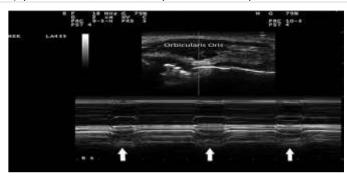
M-mode ultrasound of orbicularis oris muscle in a patient with synkinesis. The image was captured while the patient blinked her eye. Top of the figure shows B-mode image of the transverse view of the orbicularis oris muscle with the position of the M-mode beam (vertical line) over the muscle. M-mode trace at the bottom of the figure shows contraction of the orbicularis Oculi (white arrows) during eye blinking.
